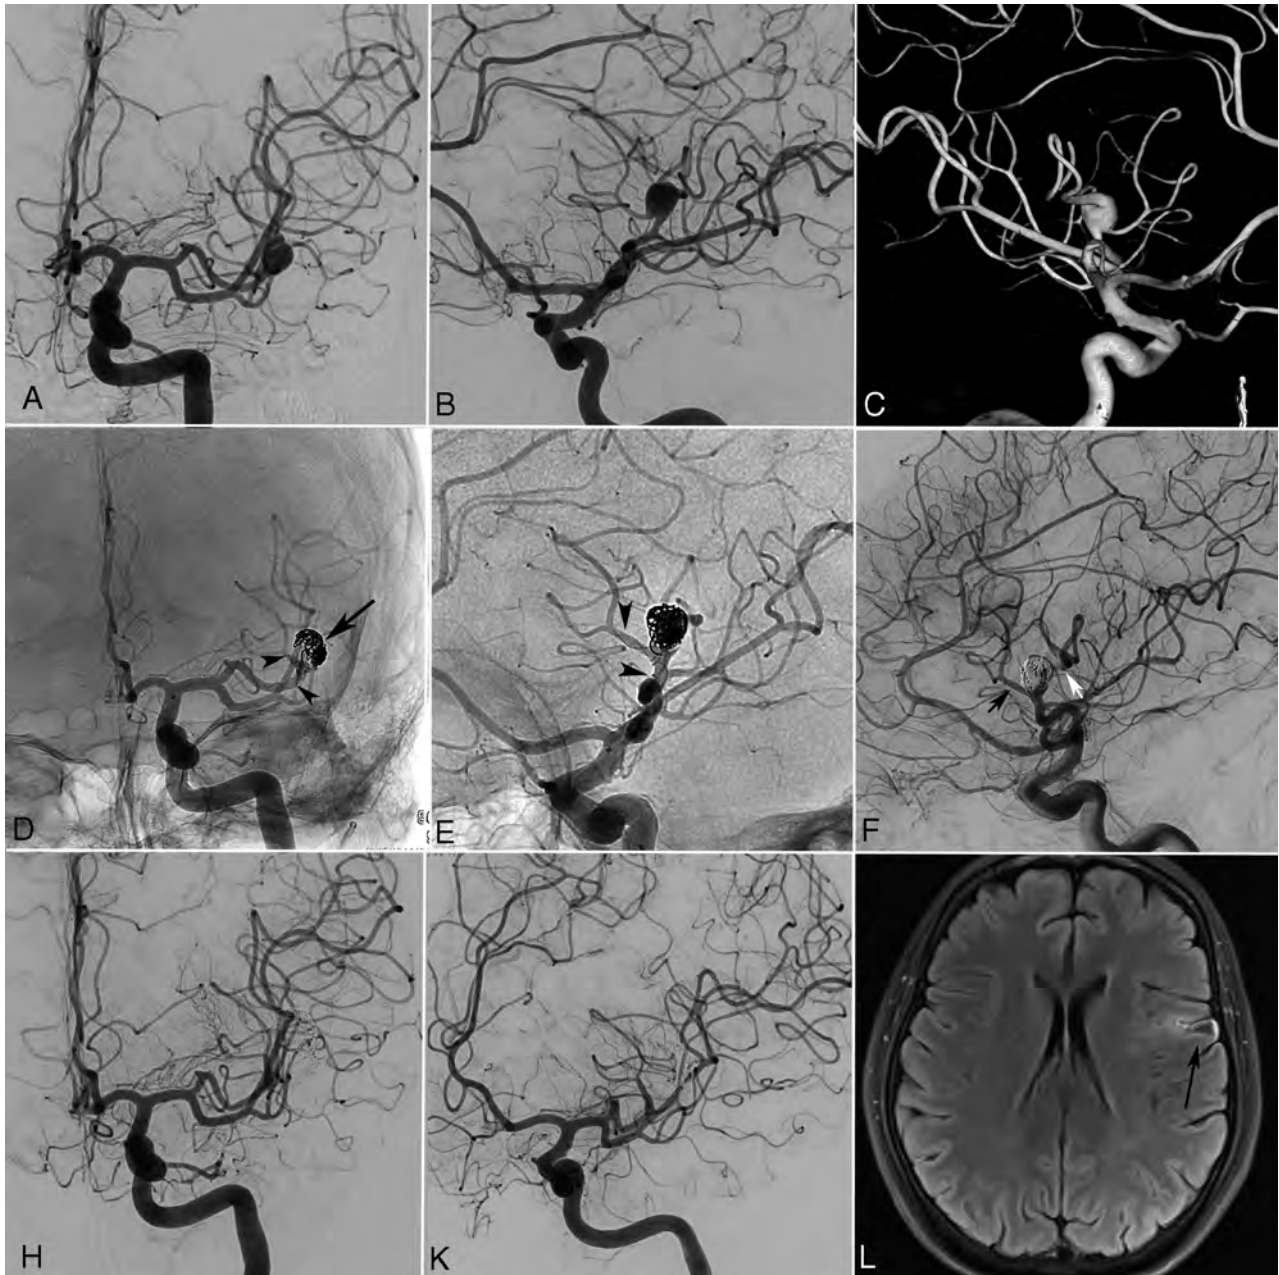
An adult patient with a left insular segment MCA aneurysm. A–C, Preprocedural DSA and 3D reconstructed angiography images show an insular segment MCA aneurysm with a very complex morphology. Two cortical stem arteries of the superior trunk originate from the neck and the superior-medial wall of the aneurysm sac. D and E, Immediate postprocedural nonsubtracted angiography images show the deployment of a self-expandable braided stent (*arrowheads*) into the stem artery that arises from the neck, extending proximally to the superior trunk. The sac of the aneurysm is partially coiled. Only the lateral compartment of the aneurysm sac is coiled to sustain the patency of the stem artery arising from the superior-medial wall of the sac. The *arrow* shows the coil mesh inside the aneurysm sac. F, Immediate postprocedural DSA image shows the patency of 2 stem arteries that arise from the neck (*black arrow*) and sac of the aneurysm (*white arrow*). H and K, Thirty-six-month follow-up DSA images demonstrate complete occlusion of the aneurysm. L, Follow-up MR image (FLAIR) shows a small cortical infarction (*arrow*) in the left frontal operculum. The mRS score of the patient was 1 during the clinical follow-up.
